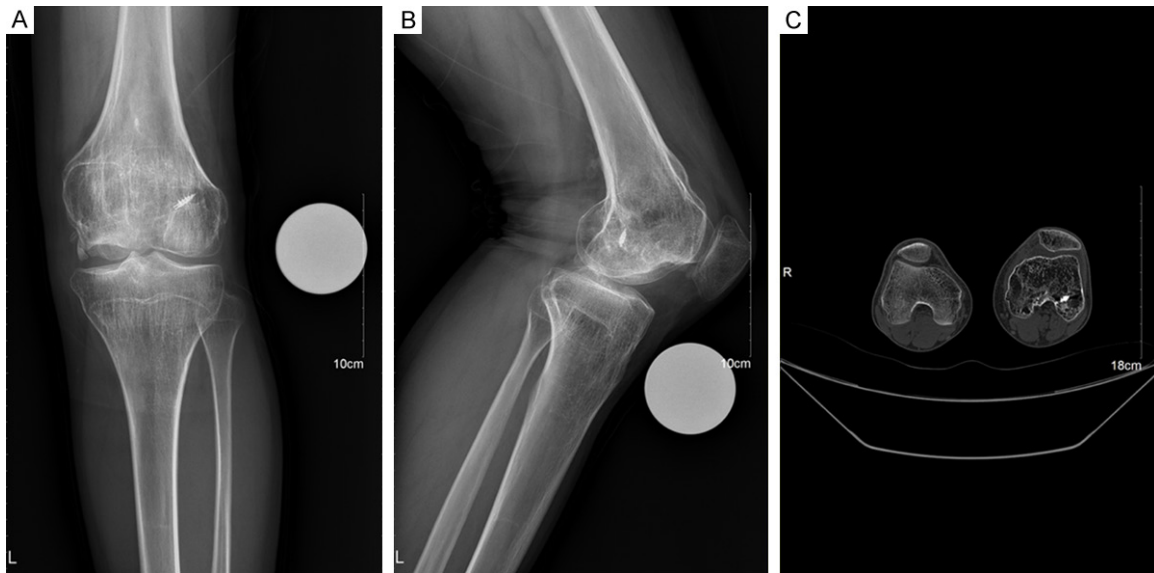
A 19-year-old man with traumatic arthritis of left knee. A. Posteroanterior X-ray of left knee; B. Lateral X-ray of left knee; C. CT of bilateral lower limbs.
